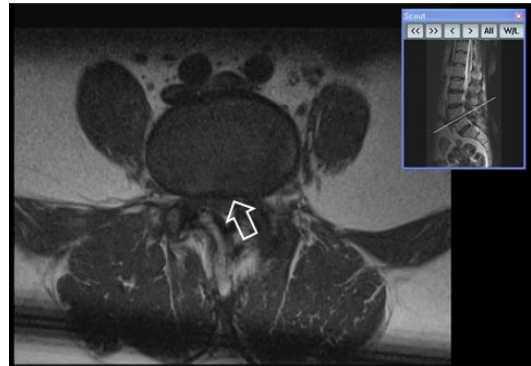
MRI of the lumbar spine
